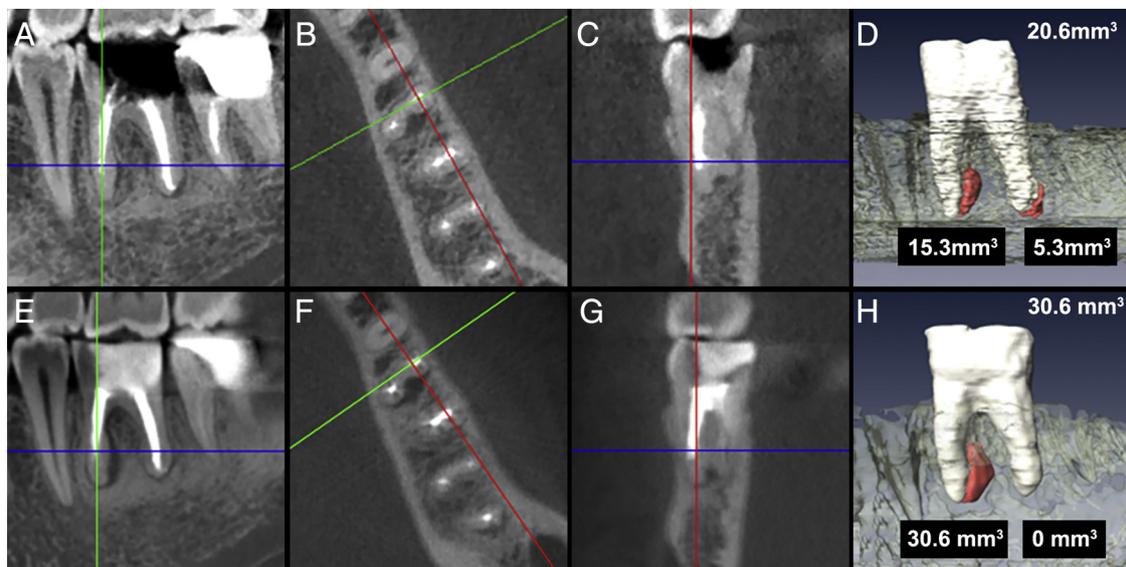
The (A–D) preoperative and (E–H) 4-year postoperative CBCT images of tooth 36. With a previous canal transportation, the canal patency could not be achieved in the mesial root during retreatment. Although the periapical radiolucency around the distal root completely resolved, the radiolucency adhered to the mesial root enlarged. The volumetric measurement revealed an enlargement in the volume of radiolucency from (D) 20.6 mm³ at the preoperative assessment to (H) 30.6 mm³ at the 4-year follow-up evaluation. The retreatment outcome of the tooth was determined as a failure. A surgical intervention was considered and recommended in subsequent planning.
